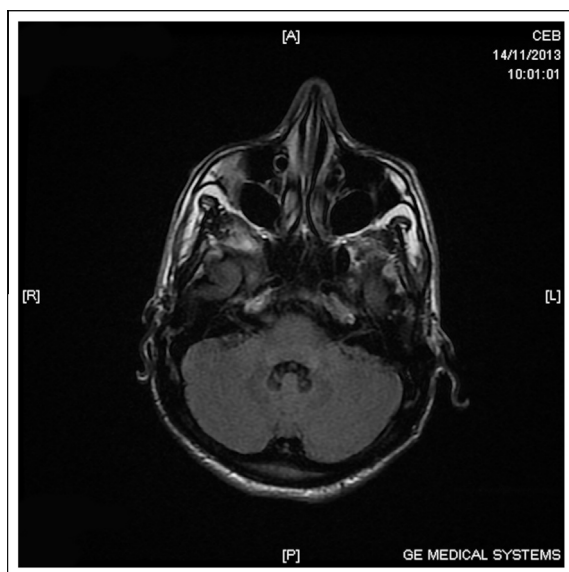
MRI on day 16 showing improvement.
